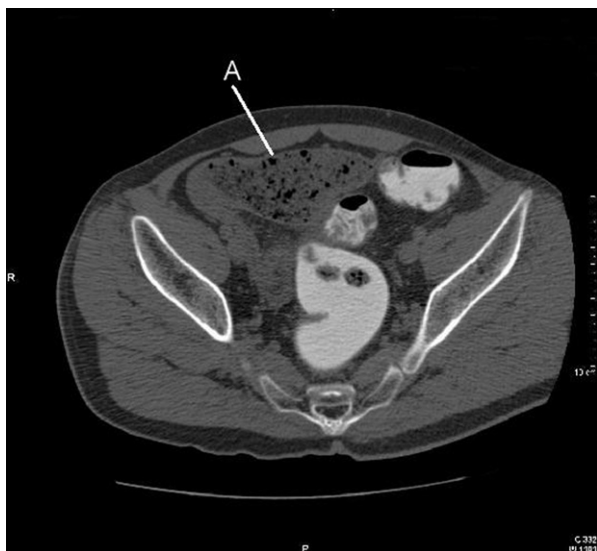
CT scan: A indicate the giant Meckel's diverticulum.
